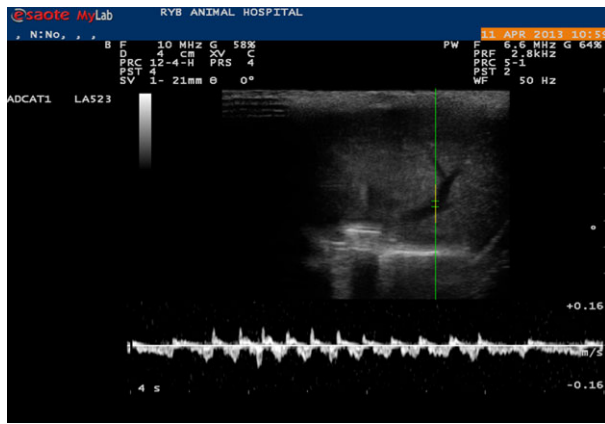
B-ultrasound observation of hepatic veins in the rings group, 2W postoperation.
